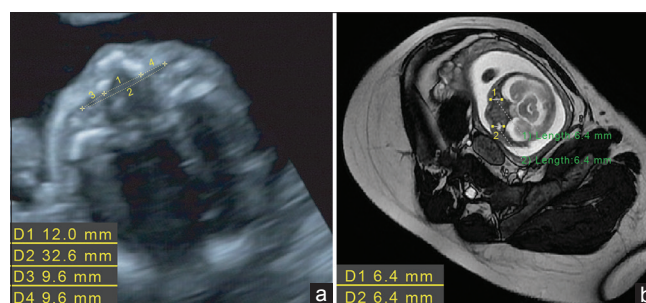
Prenatal ultrasonography (US) imaging of the first fetus. (a) Abdominal US: the inner canthal distance (D1) is long and the outer canthal distance (D2) is normal. The orbital margin diameters (D3 and D4) are small. (b) Abdominal magnetic resonance imaging: anterior–posterior ocular diameters (D1 and D2) are small
